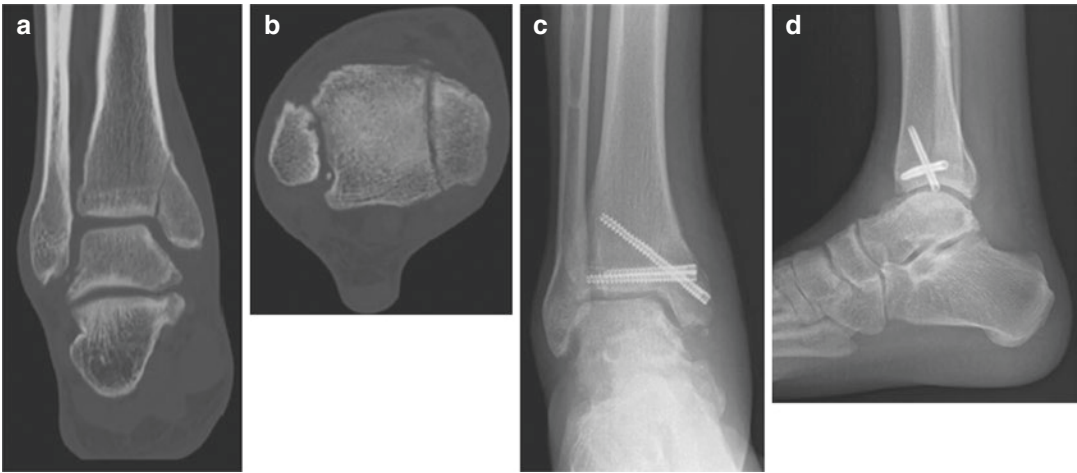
(a) Coronal CT image of a medial malleolar stress fracture in the ankle of an elite athlete. Note the talar varus deformity alignment. (b) Axial CT image of a medial malleolar stress fracture in the ankle of an elite athlete. Note the anterior small fragment. (c) Postoperative
